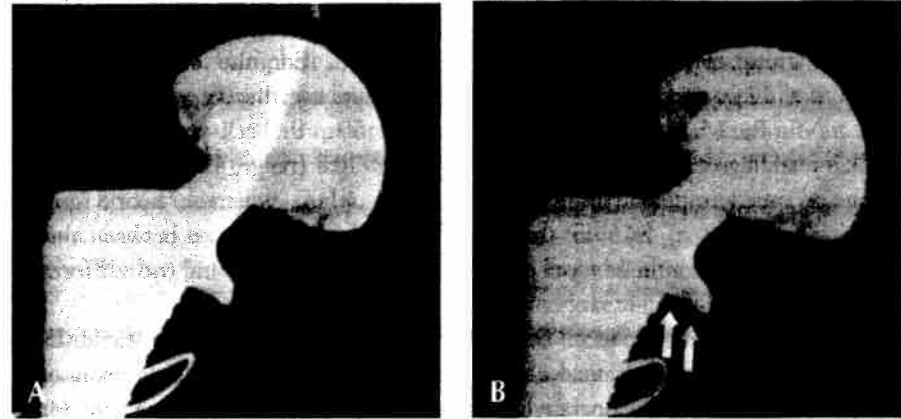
Radiographs demonstrating 5 of 96 hips (5%) that developed a radiolucency, 1 × 1 mm to 2 × 2 mm in size, directly beneath the collar devoid of porous coating (arrows). A, Postoperative radiograph. B, Radiograph obtained at 6-year follow-up.
